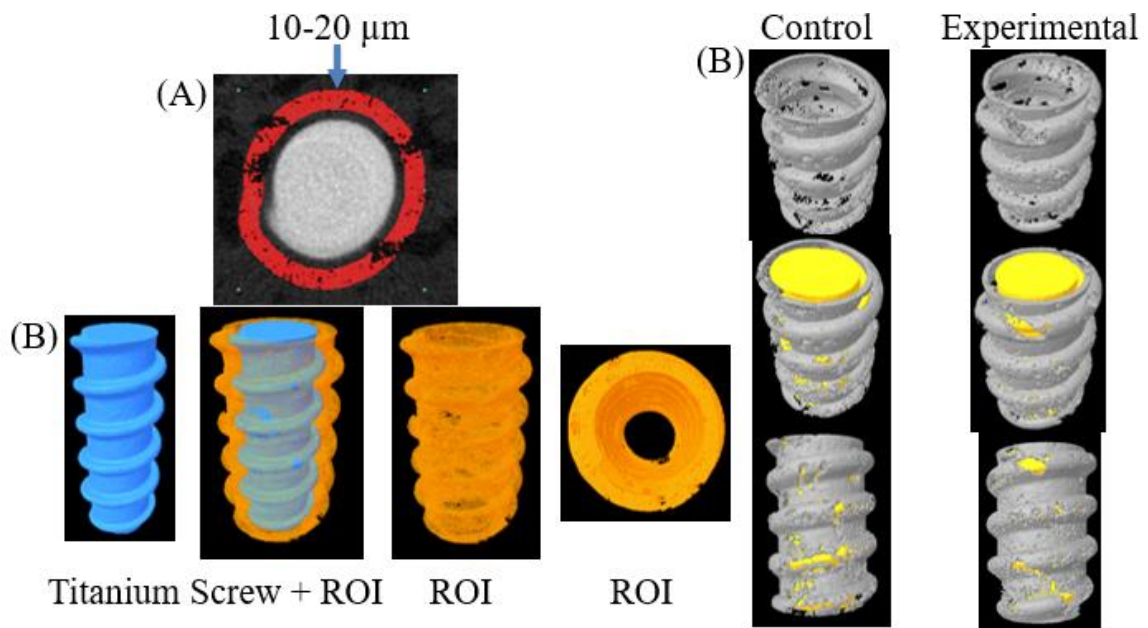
μ CT 3D Renderings & ROI. (A) 10-20 μ m ROI. (B) MSIs were segmented out and 3D ROI remained.
